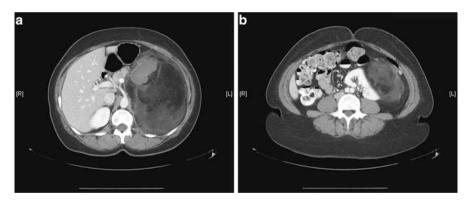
Contrast enhanced axial CT images (a, b) of a left adrenal myelolipoma
